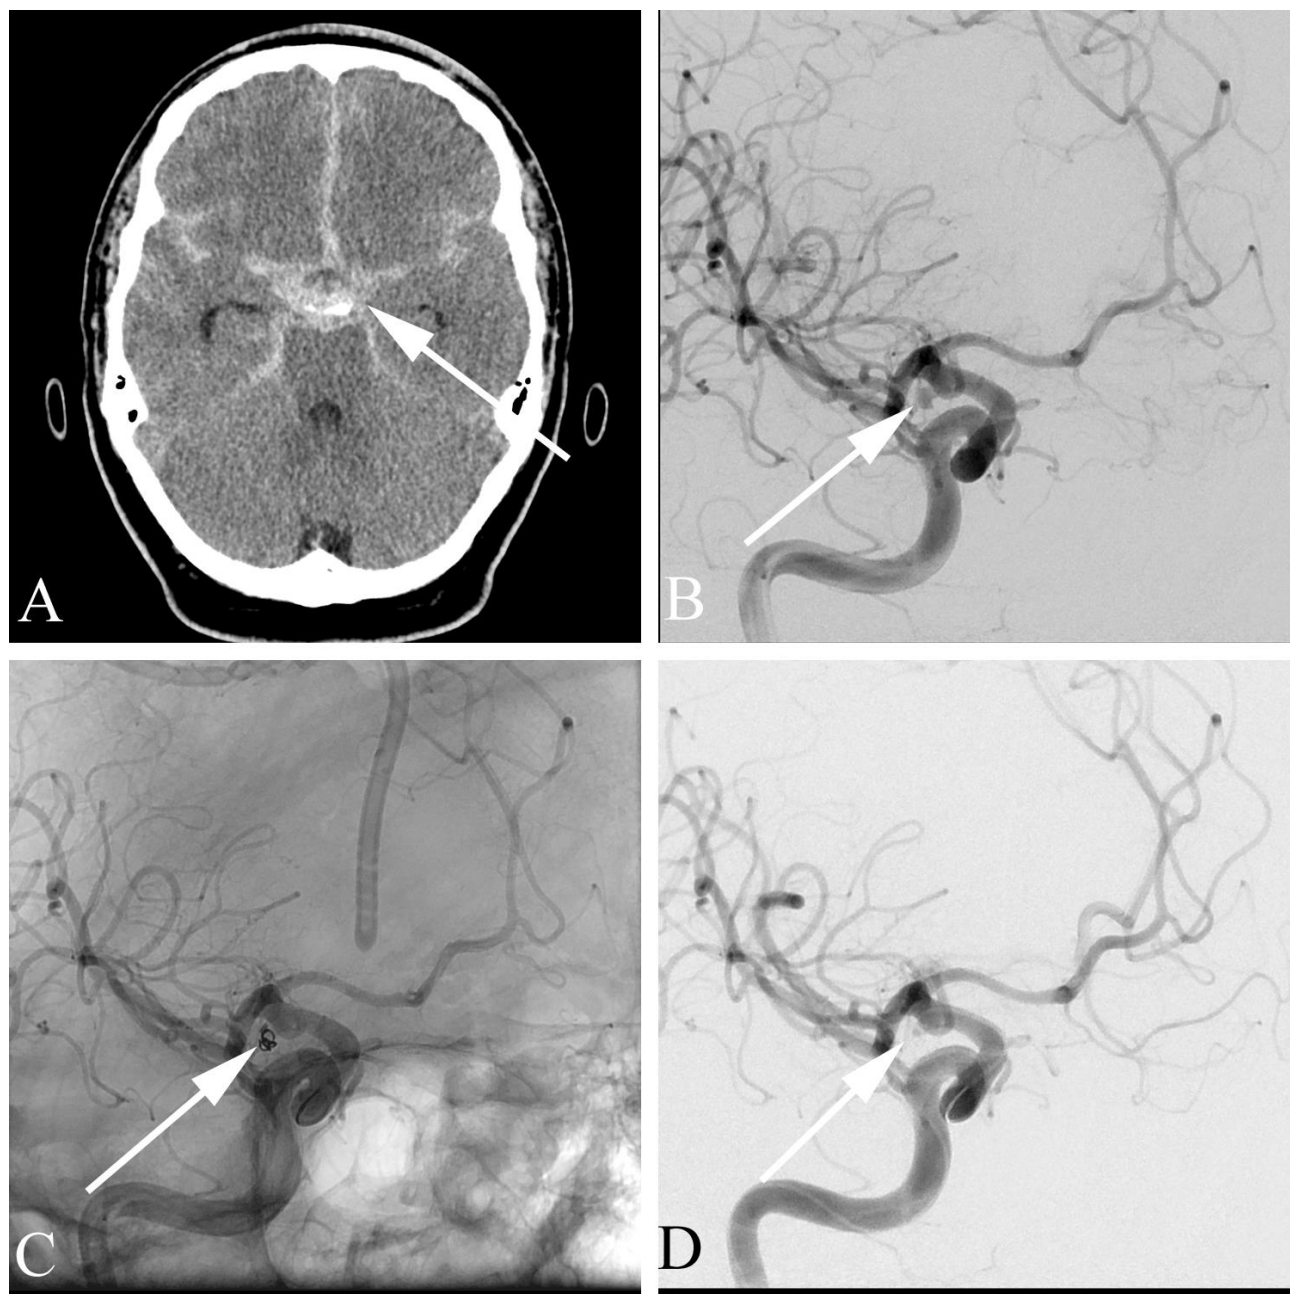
Subarachnoid hemorrhage from a bleeding aneurysm in a 60 year old man with thunderclap headache, nausea, and vomiting. A. Axial unenhanced CT study shows extensive subarachnoid hemorrhage in the suprasellar cistern (arrow) with extension between the hemispheres, around the brainstem, and along the sulci of the temporal lobes. B. Oblique image from catheter angiography demonstrates an aneurysm off of the distal internal carotid artery. C. Oblique image (nonsubtracted) from catheter angiography following coil deployment shows the coil at the former location of the aneurysm. D. Oblique image (digitally subtracted) from catheter angiography following coil placement demonstrates minimal flow into the aneurysm following successful coil placement (compare with "B").
